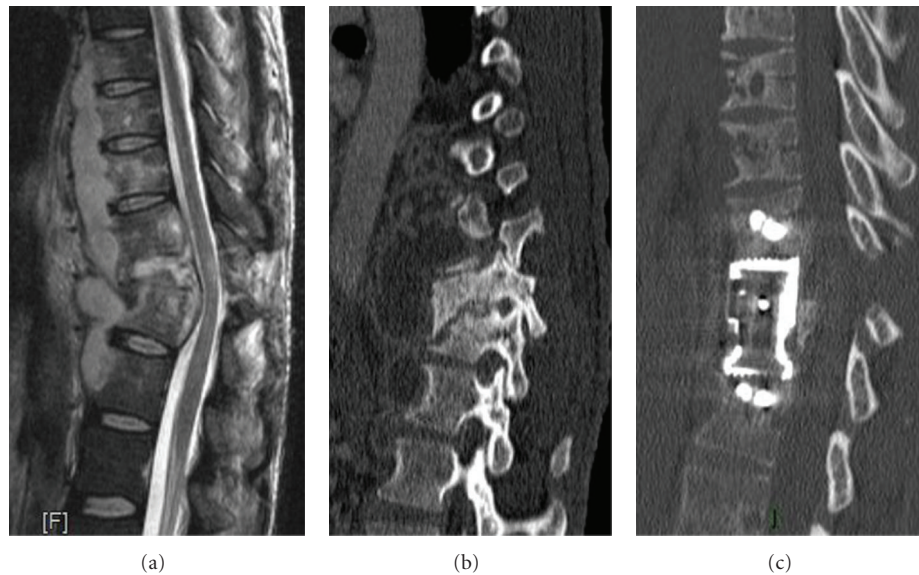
(a) Sagittal MRI T2: here the infectious process has involved two vertebral bodies with an initial tightening of the canal even if it is still possible to identify signs of the liquor around the spinal cord. The paravertebral extension is clearly visible. (b) Sagittal CT: it highlights the marked kyphotic deformation caused by the complete erosion of the bone by the infection, in particular to the inferior vertebral body. (c) Postoperative sagittal CT: highlighted here is the correct positioning of the mesh as well as the restitution of the correct curvature to the dorsal rachises.
